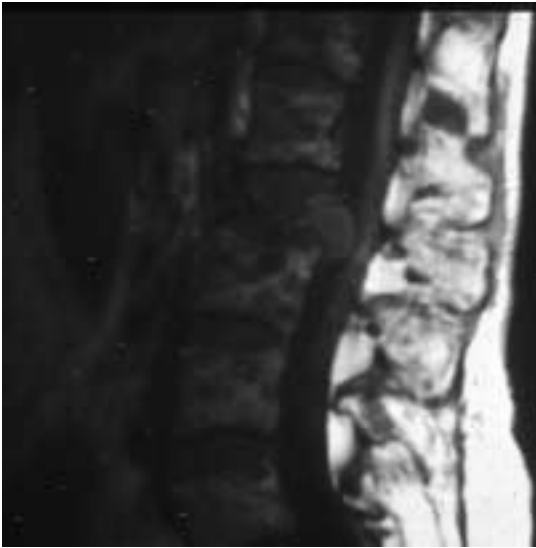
This lateral spine radiograph shows extensive tumour deposits from multiple myeloma. Acupuncture should not be used in the vicinity of any areas of instability.
